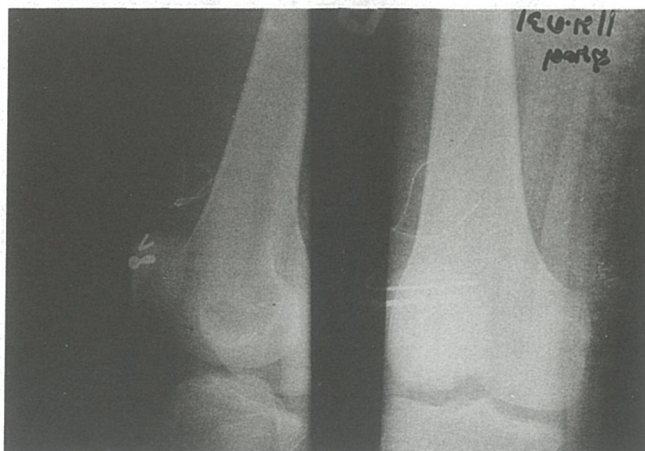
Anteroposterior and lateral radiographs showing the left patella after internal fixation with one Kirschner wire and one small cancellous screw.
